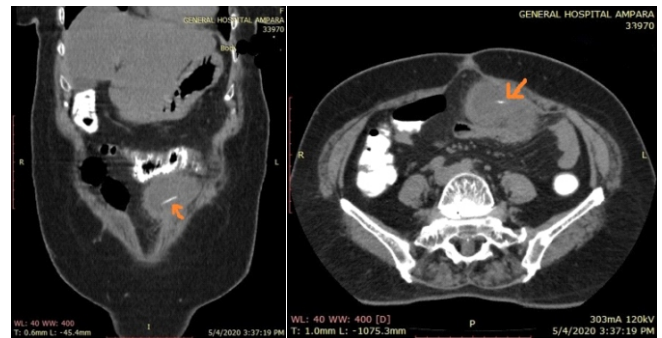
Foreign body within the mass on CT
